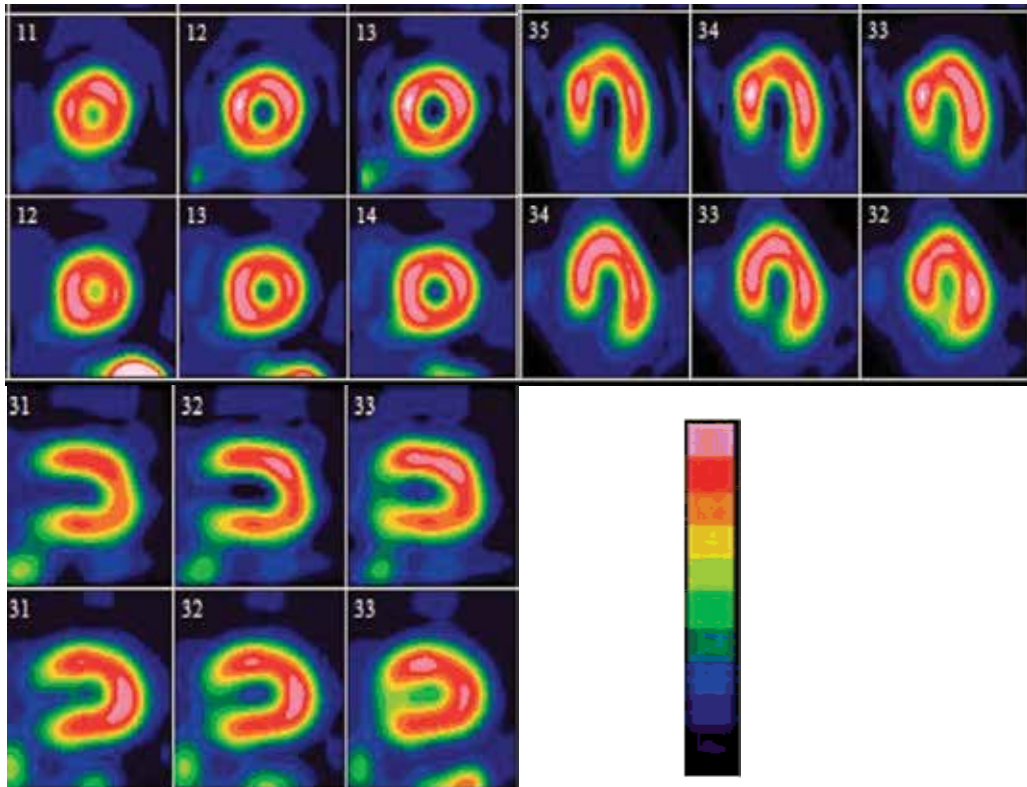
Stress (top row) & Rest (bottom row) images in the short axis (SA), horizontal long axis (HLA) and vertical long axis (VLA) show normal homogenous tracer uptake. Gated images showed normal left ventricular ejection fraction (not shown). This is a normal SPECT MPI study.
